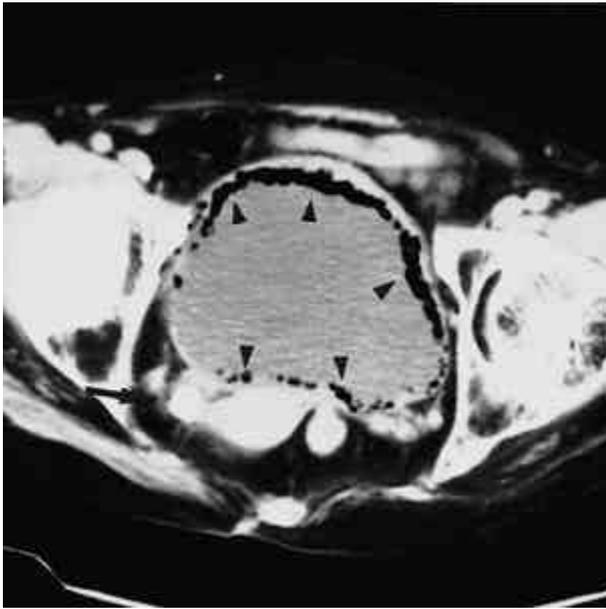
Postcontrast pelvic CT scan shows numerous gas bubbles along the entire wall of the urinary bladder (arrow heads) and right distal ureteral stone (arrow).
